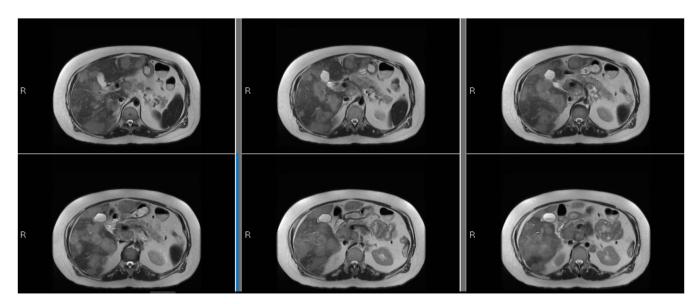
T2-weighted axial magnetic resonance images demonstrating greater than 40 diffuse hepatic metastases, the largest measuring 8.5 × 5.3 cm in segment 5/6 and 6.2 × 6.9 cm in the right hepatic dome. Porta hepatis nodal conglomerate measuring 3.9 cm is also noted.
